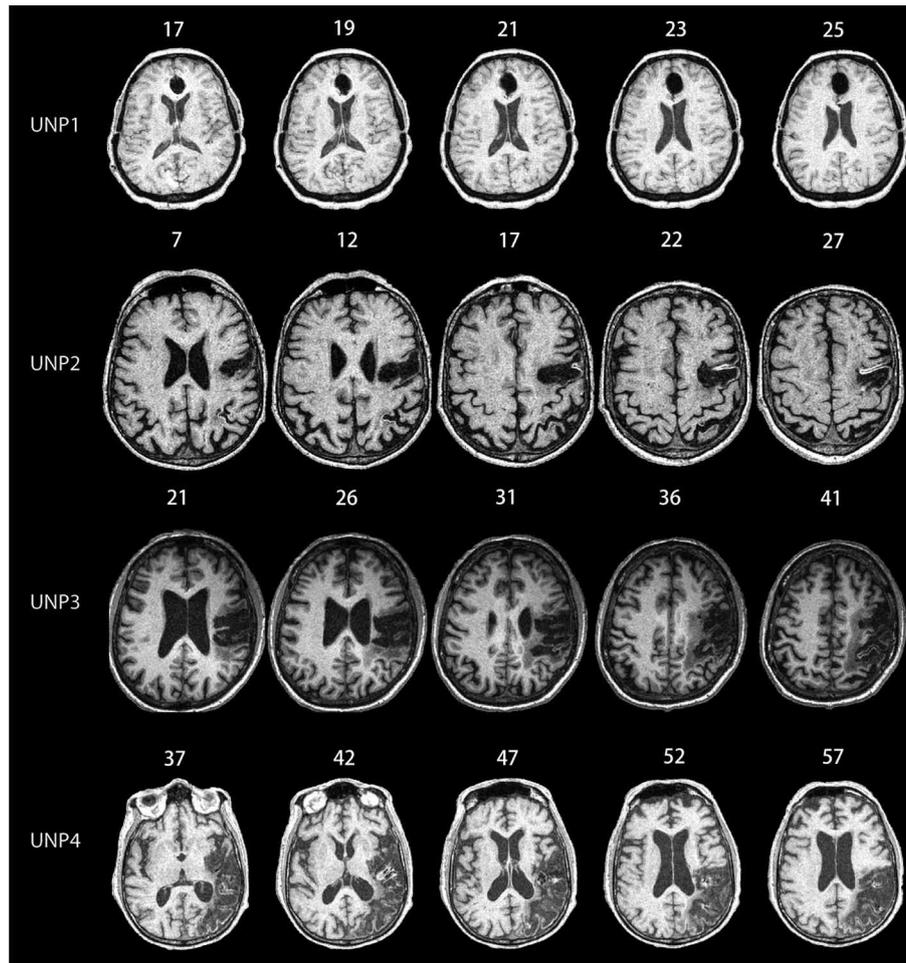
MRI scans for all of the unilateral neglect patients (UNPs) included in the study. Numbers listed above each picture depict the MNI coordinates. UNP1 has lesions in the anterior cingulate, orbitofrontal, and thalamic regions. UNP2 has lesions in the frontal, parietal, and occipital
